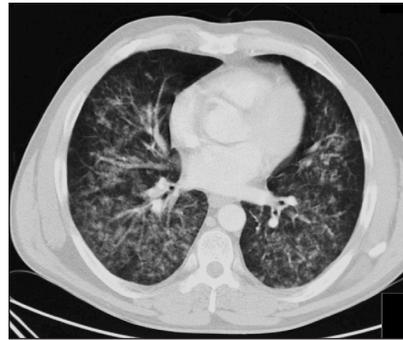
Computed tomography scan of the patient's thorax showing peribronchovascular parenchymatous densities with areas of ground-glass opacity.
